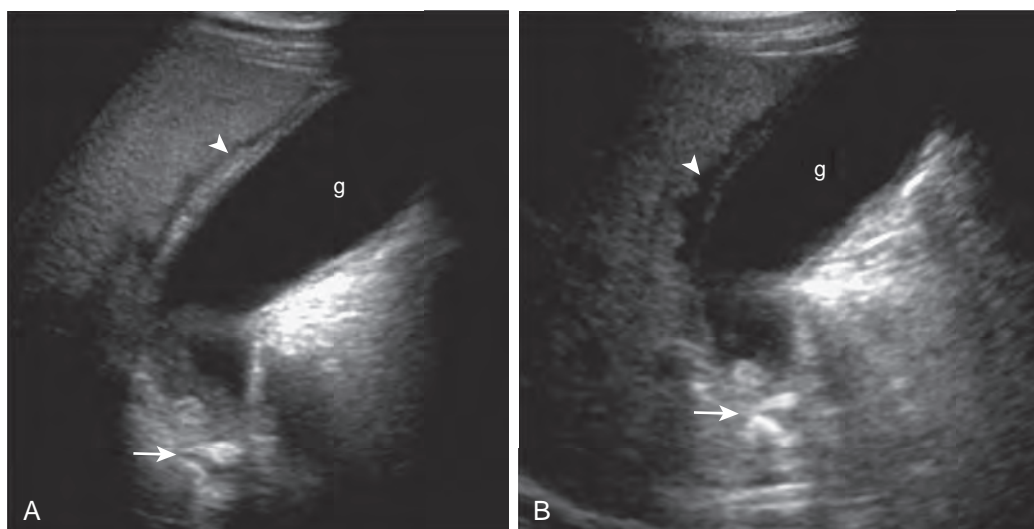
Acute cholecystitis: ultrasound. A. Gallbladder (g) is distended, with mural thickening (arrowhead) and a stone in the gallbladder neck (arrow). Sonographic Murphy sign was present. B. In the upright position, the gallbladder (g) is distended, and pericholecystic fluid is evident (arrowhead). Stone (arrow) does not change location, confirming impaction in gallbladder neck.
